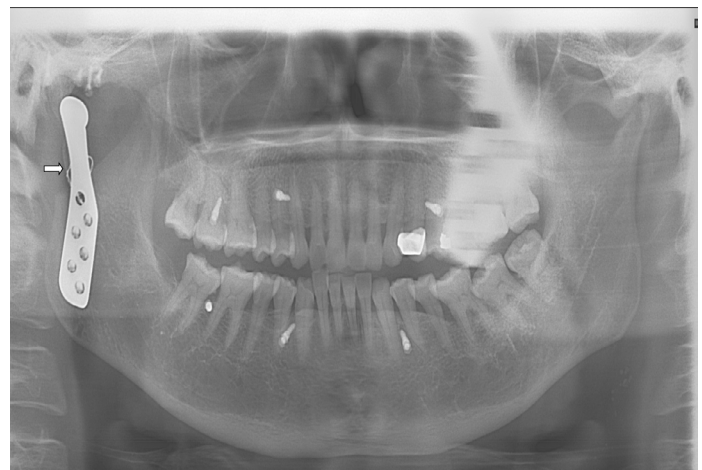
Post-operative panoramic X-Ray with fixation of the preserved condylar block using a steel wire (arrow).
